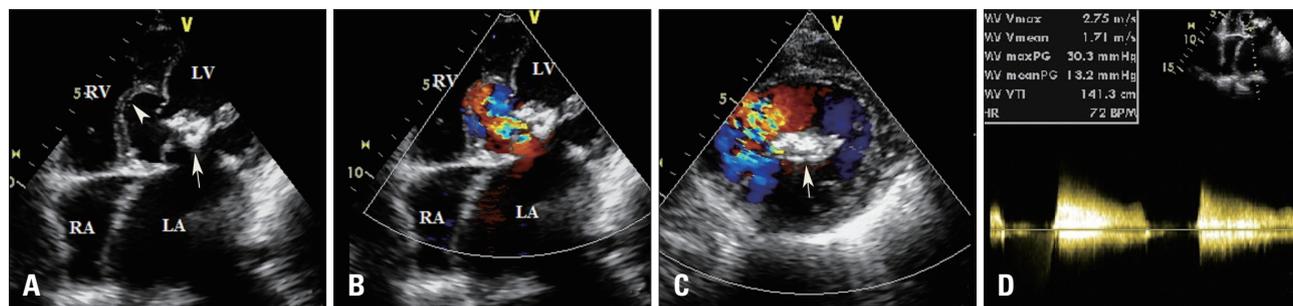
Two dimensional transthoracic echocardiography. The presence of severe calcific mitral stenosis can be seen in apical four chamber as well as short axis view (arrow in A and C) with a mean and peak resting gradient of 30 mm Hg and 13 mm Hg respectively on continuous wave Doppler (D). The jet of the mitral stenosis is eccentrically directed towards the basal interventricular septum (color flow in B and C) likely responsible for the aneurysmal defect of the basal septum (arrowhead in A). Also note the marked dilatation of the LA. LA: left atria, LV: left ventricle, RA: right atria, RV: right ventricle.
